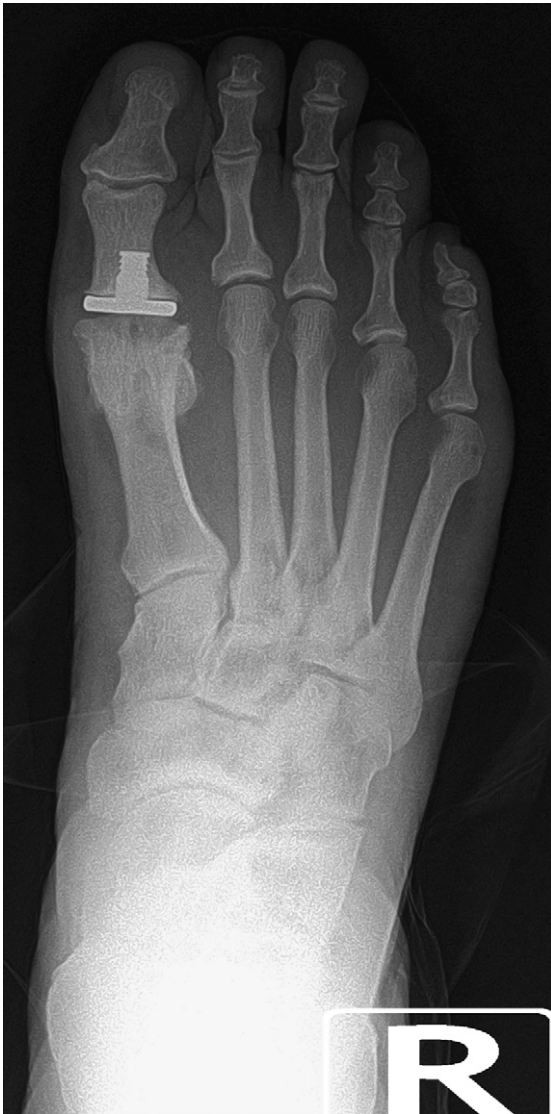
Hemi-implant arthroplasty. Postoperative dorsal-plantar radiographic view demonstrating result of hemi-implant arthroplasty of first metatarsophalangeal joint.
